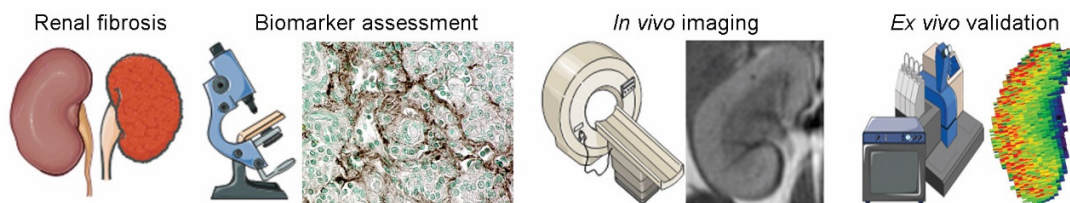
Molecular MRI captures therapy effects in renal fibrosis.
